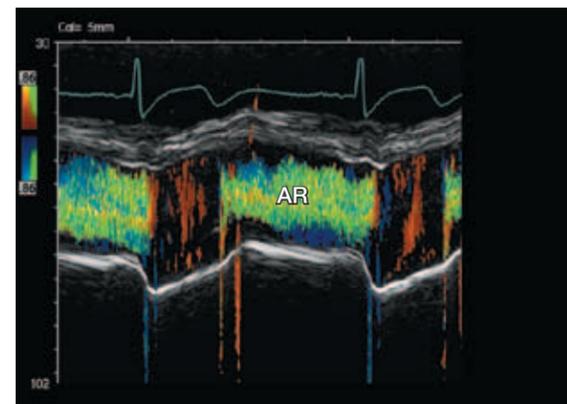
This colour Doppler M-mode trace displays aortic regurgitation (AR). This trace was acquired from the parasternal long axis of the left ventricle with the M-mode cursor transecting the left ventricular outflow tract (LVOT). Observe the mosaic AR jet within the LVOT during diastole. Measurement of the AR jet height and the LVOT height can be used in the semiquantification of the AR severity.
